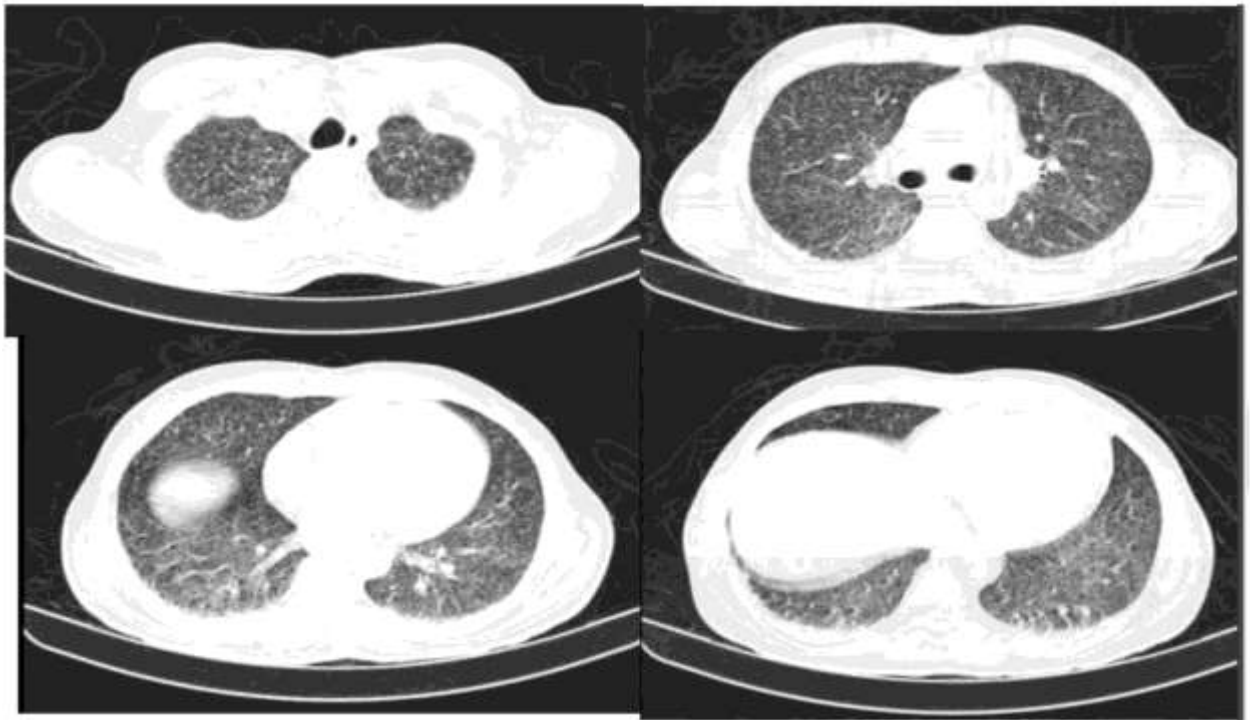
CT thorax demonstrating miliary deposits
